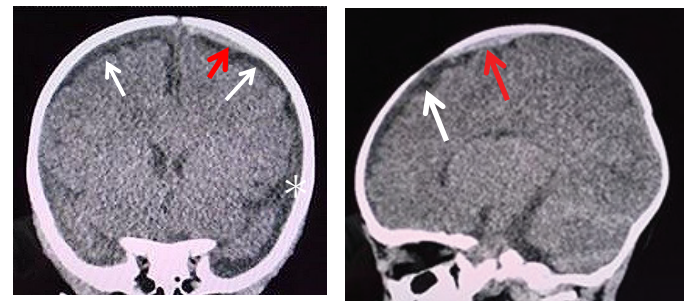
CT taken for sepsis workup at the age of one month
